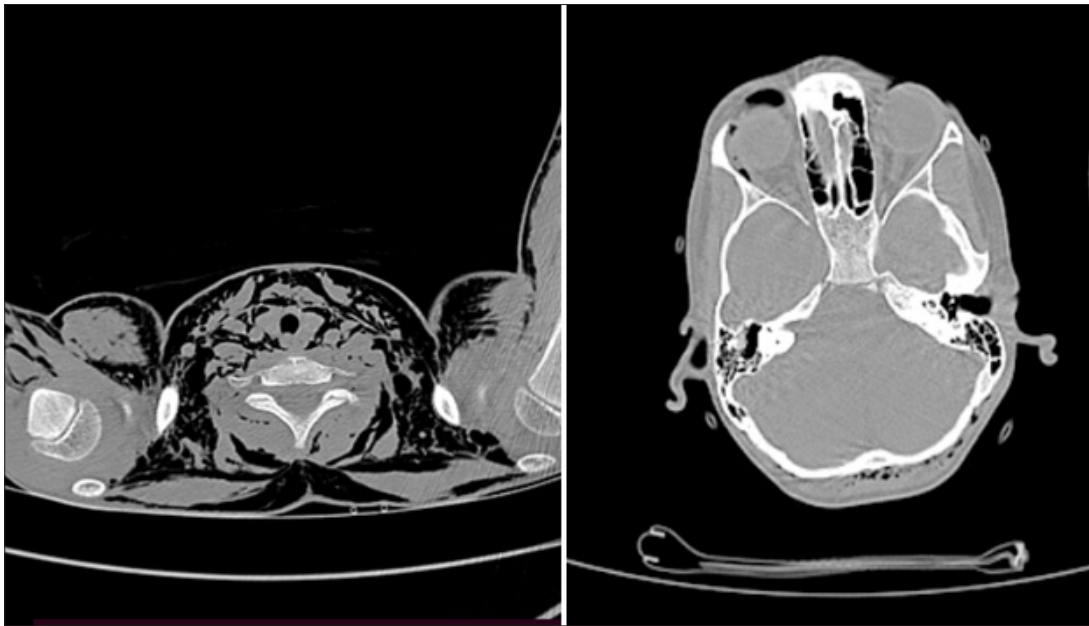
axial section of Neck & head CT-scan shows air in the subcutaneous tissue extending to periorbital and upper arm region
